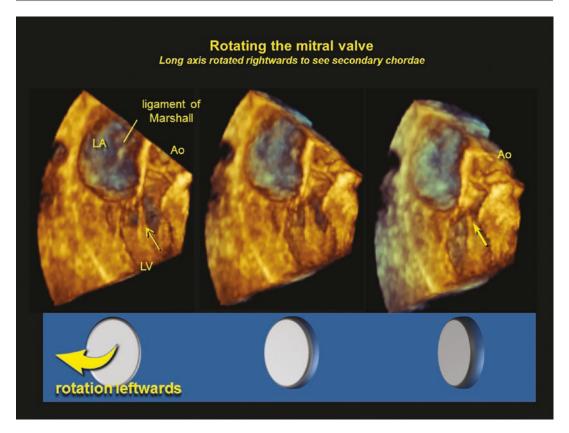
Three-dimensional echocardiographic still frame of the long axis of the left ventricle showing the left atrium, mitral valve and left ventricle from the septal side
